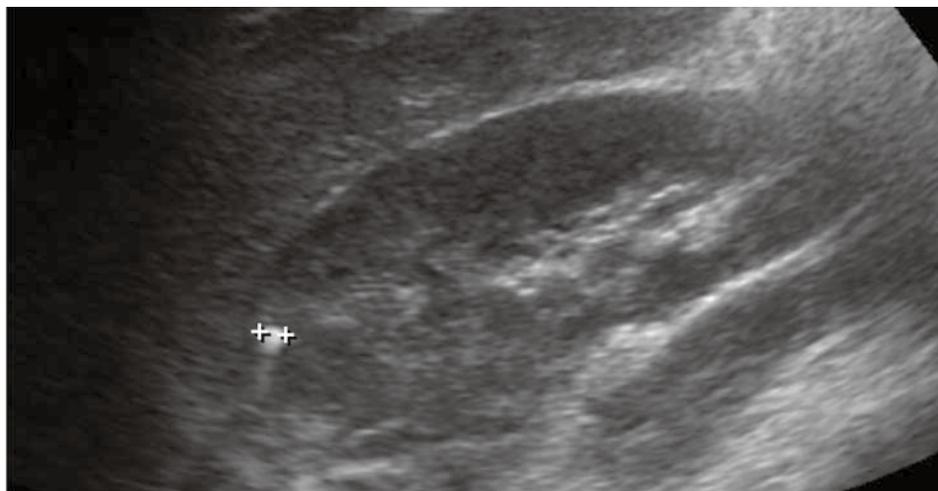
Ultrasonographic image showing a case of renal deposit associated with MTMP. Note the small echogenic focus with comet tail artifact.
